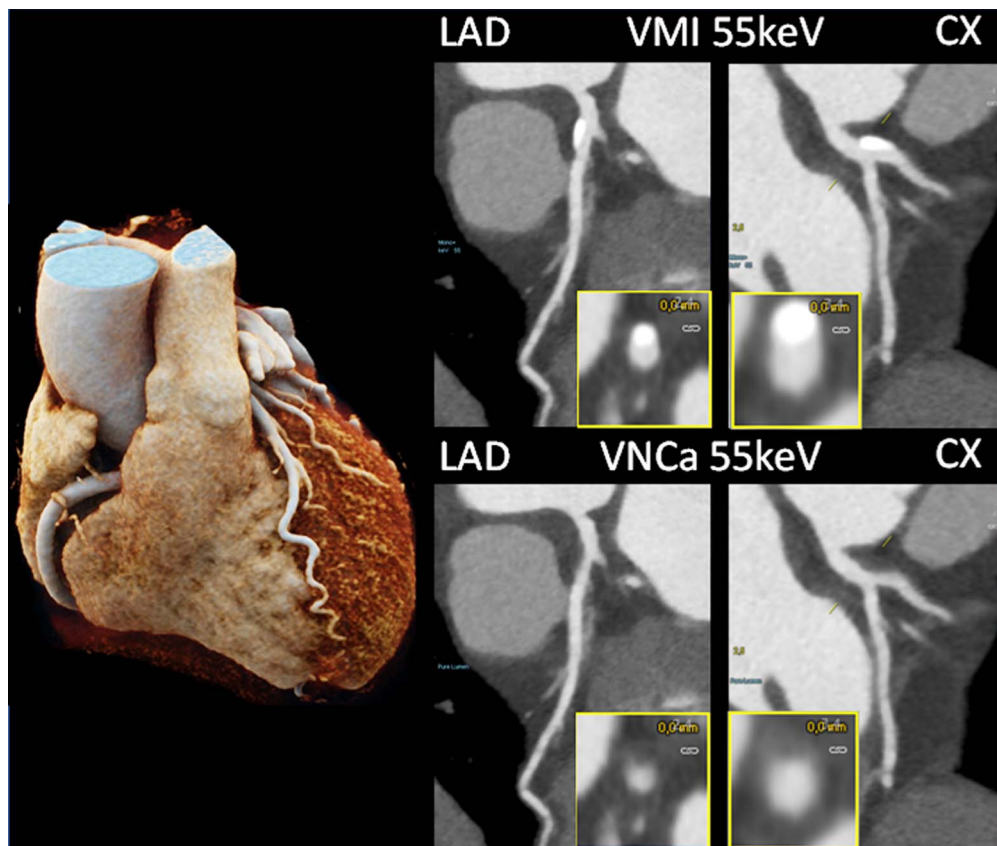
Coronary CTA images of a patient with calcifications in the LAD and CX, scanned with a PCD-DSCT (120 kV, 144×0.4 mm, 0.25 seconds rotation time, 66 milliseconds temporal resolution). The calcifications shown in the 55 keV VMIs (top) are removed in the 55 keV virtual noncalcium images (bottom). Courtesy of Dr H. Alkadhi, University Hospital Zurich, Switzerland.
